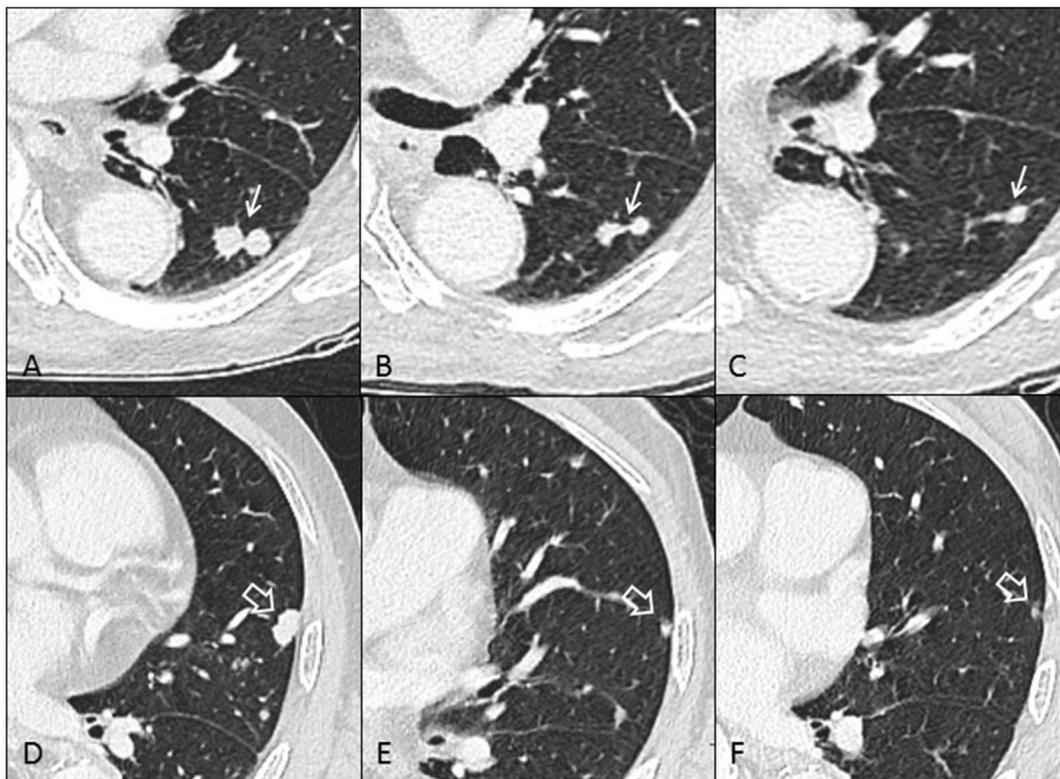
Baseline CT (A and D) demonstrates pulmonary metastases in the left lower lobe (solid arrow) and left upper lobe (open arrow). After 4 months of bicalutamide therapy, (B and E) there has been a partial response to treatment. Continued response is seen at 10 months after bicalutamide therapy (C and F). CT, computed tomography.
